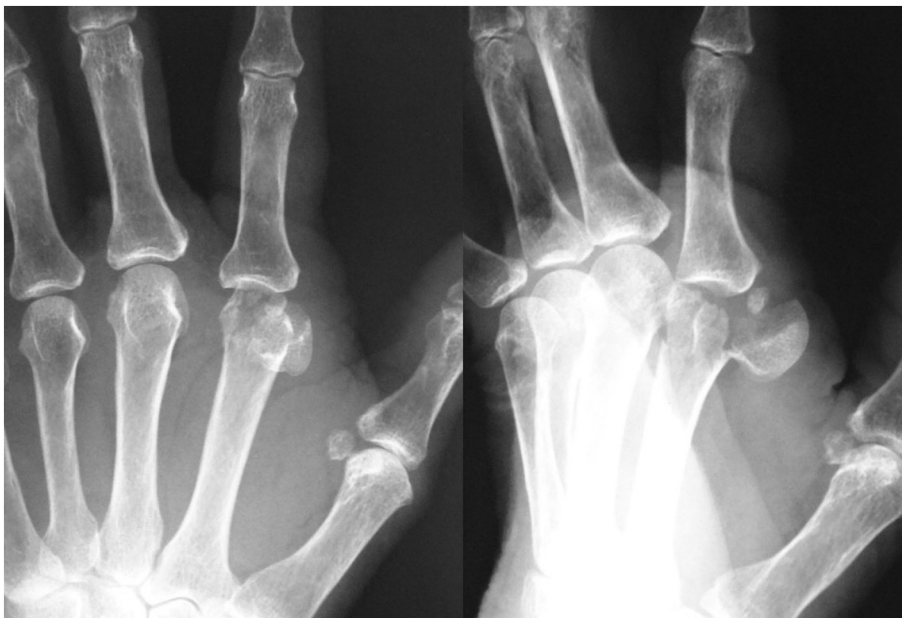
Radiography after closed reduction showing complete displacement of the second metacarpal head to the volar side.
